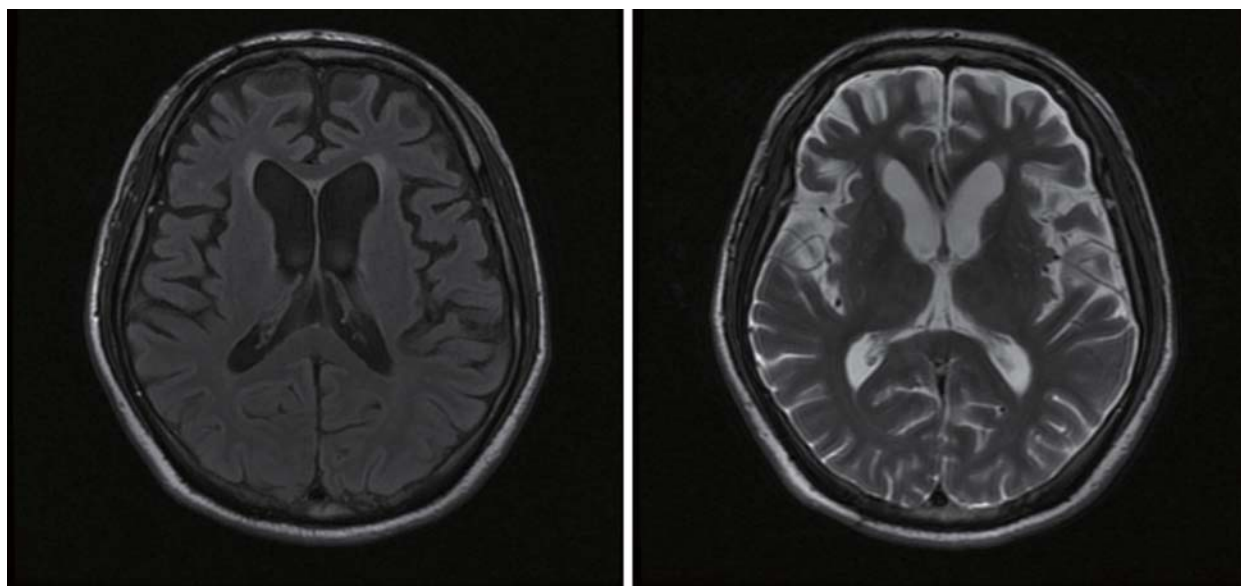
FLAIR and T2WI MRI of head in case 1 shows severe cortex atrophy in bilateral fronto-temporal area, without obvious signal changes
